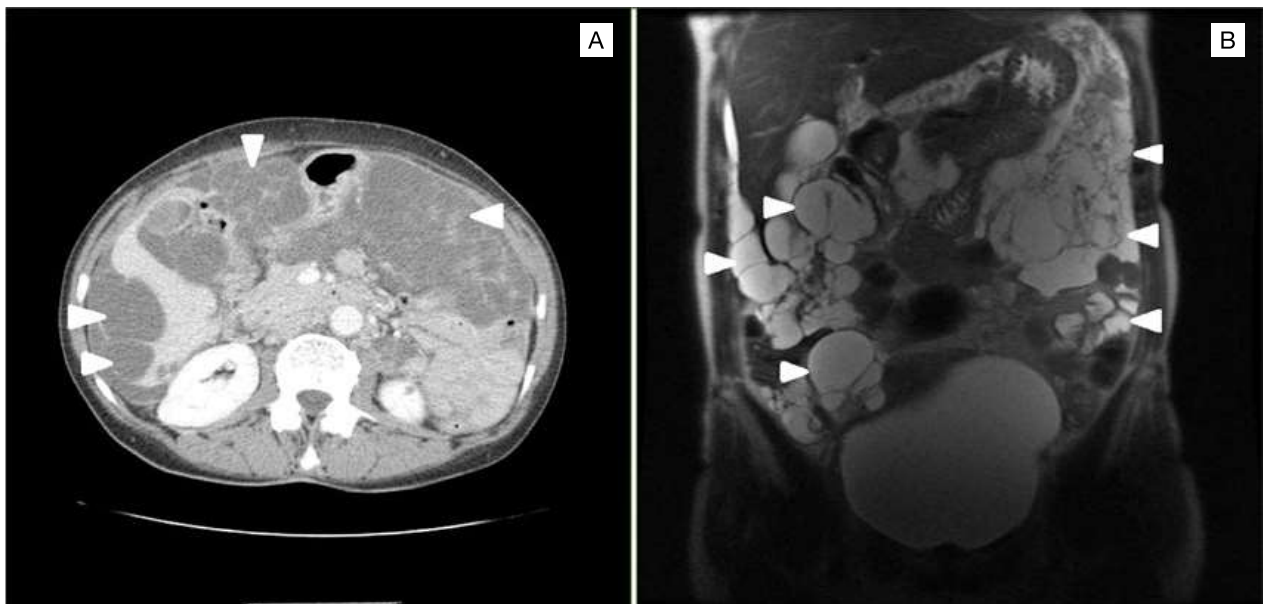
Panel A – Axial thoracoabdominopelvic computed tomography scan with multiloculated cystic lesions with solid component. Panel B – Coronal T2-weighted magnetic resonance imaging showing multicystic masses. Lesions are identified by arrowheads in both panels.
